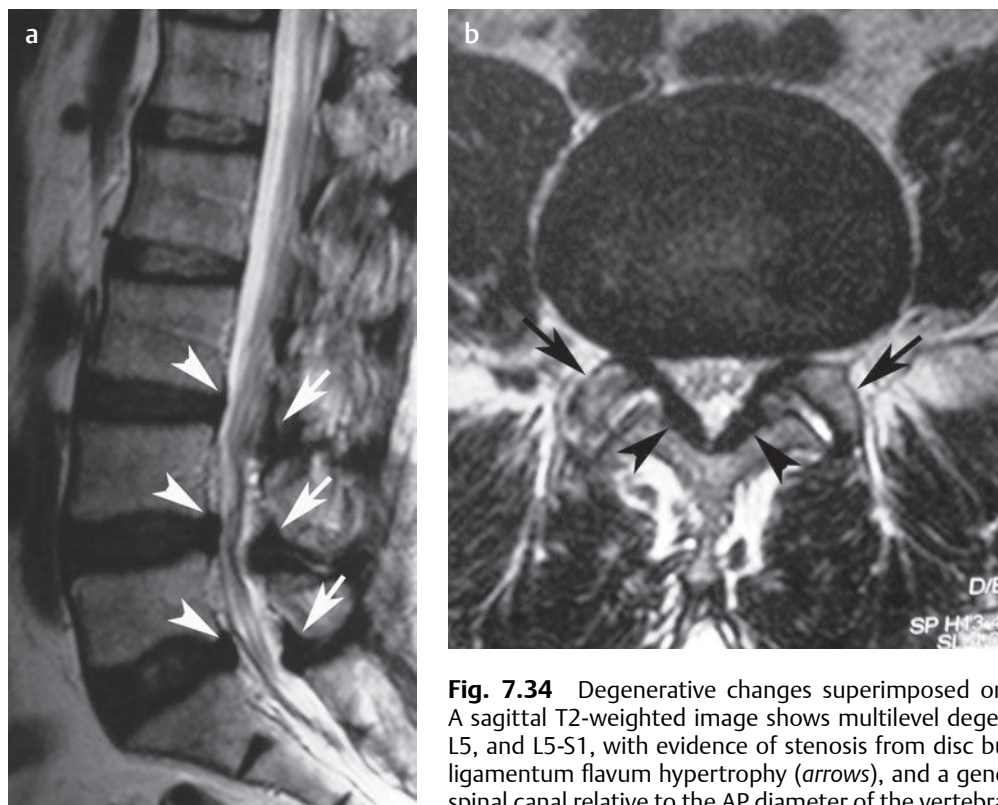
Degenerative changes superimposed on congenital lumbar stenosis. (a) A sagittal T2-weighted image shows multilevel degenerative disc disease at L3-L4, L4-L5, and L5-S1, with evidence of stenosis from disc bulges at these levels (arrowheads), ligamentum flavum hypertrophy (arrows), and a generalized narrow appearance of the spinal canal relative to the AP diameter of the vertebral bodies. (b) An axial T2-weighted image at the L4-L5 level shows minimal to moderate stenosis secondary to underlying congenital stenosis with superimposed degenerative changes, including ligamentum flavum hypertrophy (arrowheads) and facet arthropathy (arrows).[†]
